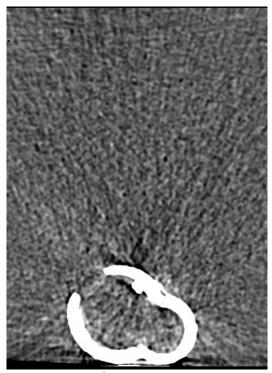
CT scan showing the anterior portion of the tibial cone, this image shows streaking artefact
